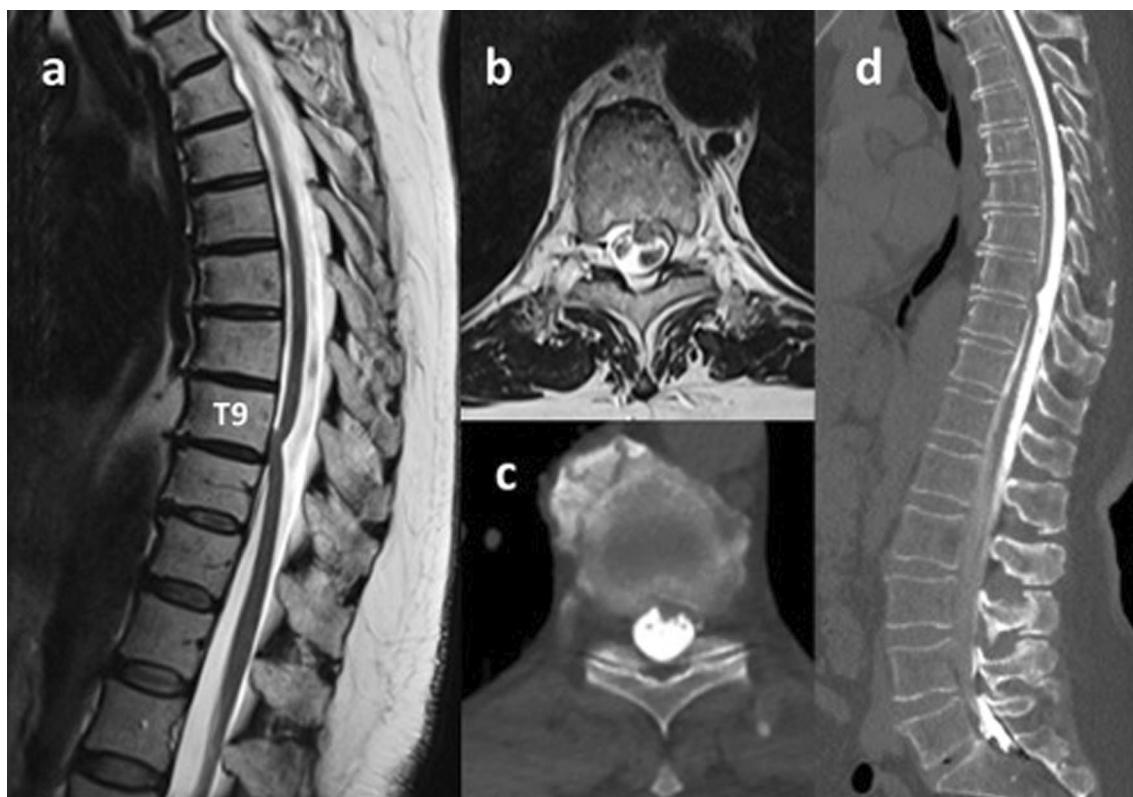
Preoperative MRI and CT-myelogram. A T2-weighted sequence sagittal MRI showing the herniated spinal cord ventrally. B T2-weighted sequence axial MRI showing the central herniation of the spinal cord through the ventral wall of the dura mater. C CT-myelogram confirms that there is no accompanying arachnoid cyst. D Sagittal CT-myelogram imaging of the spinal column
